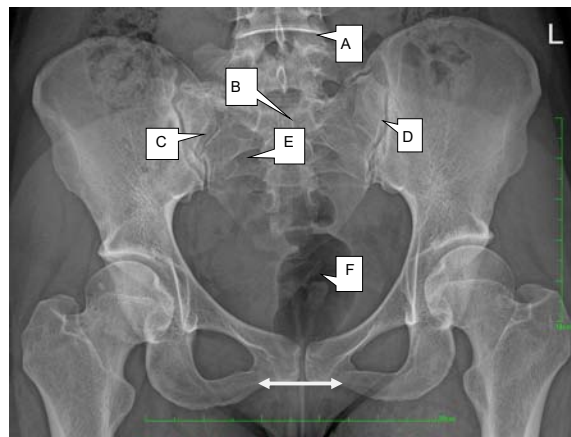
Plain anteroposterior radiograph of the pelvis.
